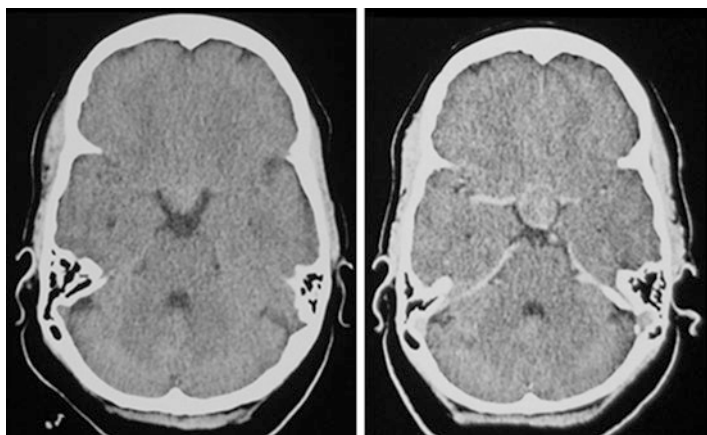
Pre and post contrast Brain CT scans showing a pituitary adenoma
